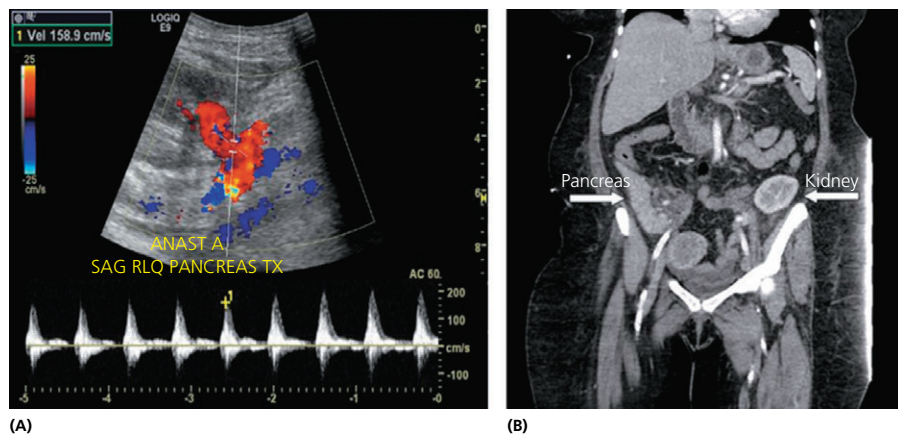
(A) Ultrasound assessment of a pancreas transplant vasculature. (B) Computed tomography scan of a simultaneous kidney transplant recipient.
